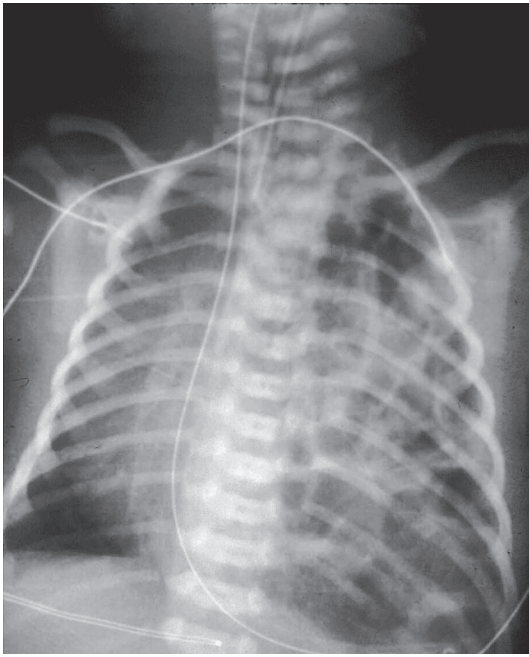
■ Typical aspect of plain radiograph from a neonate with a left congenital diaphragmatic hernia. Note the presence of bowel loops in the left hemithorax, the mediastinal deviation to the right, and the gastric tube in the chest.
